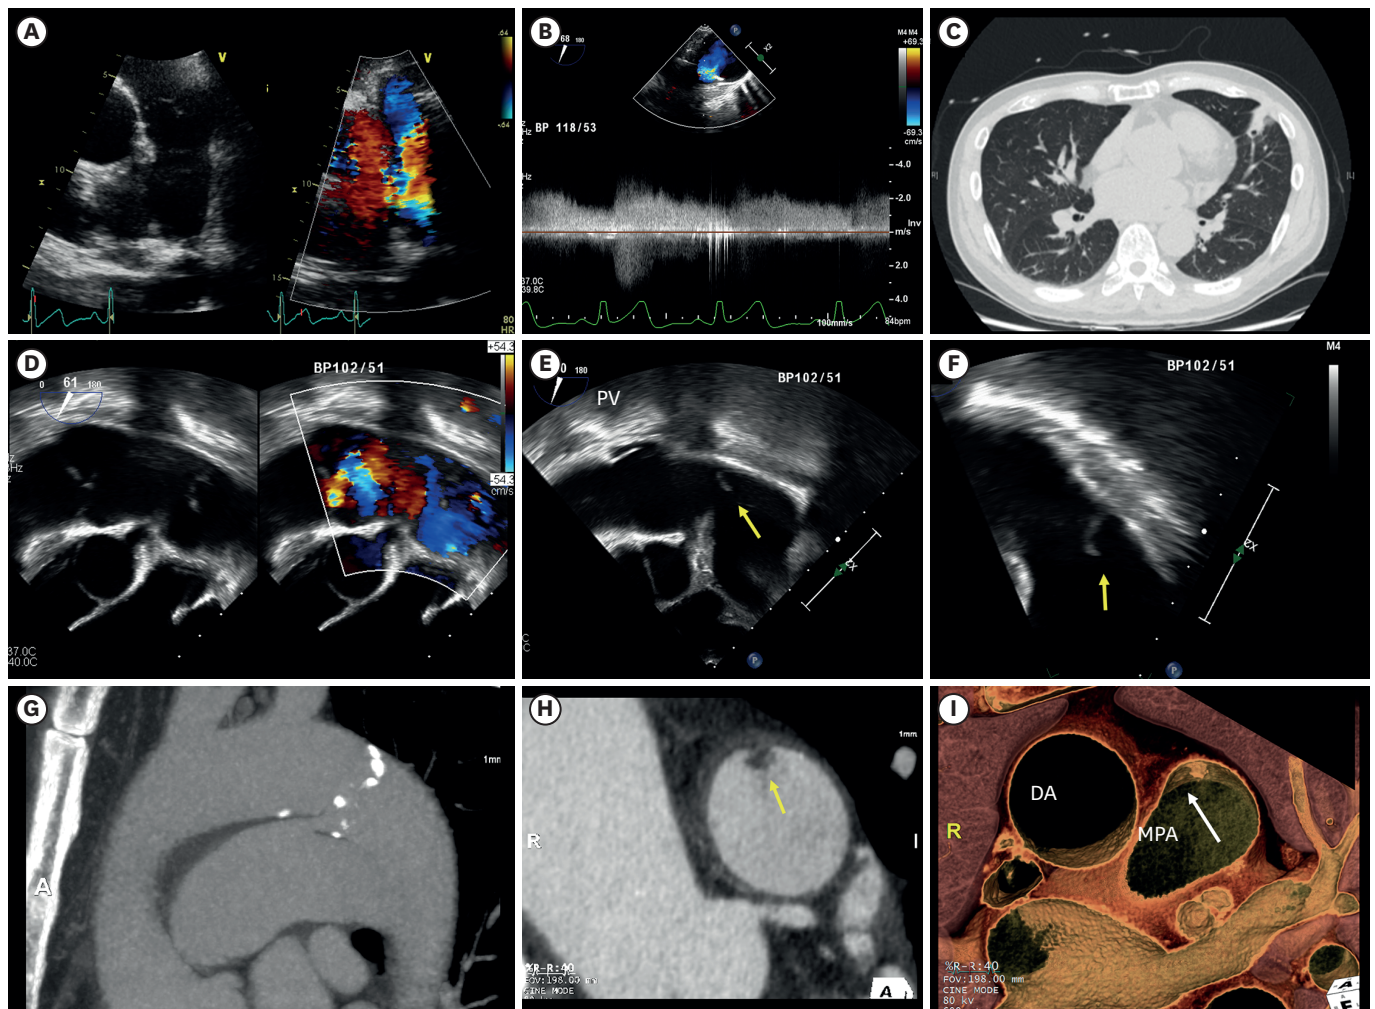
Multimodal imaging of infectious endarteritis associated with patent ductus arteriosus. (A) TTE image in the high left parasternal short-axis view showing a dilated pulmonary trunk and colour Doppler interrogation of the PDA. (B) Continuous-wave Doppler interrogation of the PDA demonstrating continuous flow from the aorta to the PA with systolic peak velocity of 4.47 m/s. (C) Chest CT demonstrated multiple consolidations with and without cavitation in both lungs, suggesting septic embolic pneumonia. (D-F) TTE of the right showed the vegetation located in line with the direction of PDA blood flow. (G) Heart CT showed a PDA (arrow) of type C (tubular) ductus that connects the proximal descending aorta to the PA with calcification (aorta side end: 8.2 mm, PA side end: 6.1 mm). (H and I) On 2D and 3D heart CT, a 0.6-cm ill-defined mobile nodular lesion was attached to the medial side of the main PA. TTE: transthoracic echocardiography, PDA: patent ductus arteriosus, PA: pulmonary artery, CT: computed tomography, PV: pulmonic valve, DA: descending aorta, MPA: main pulmonary artery.
